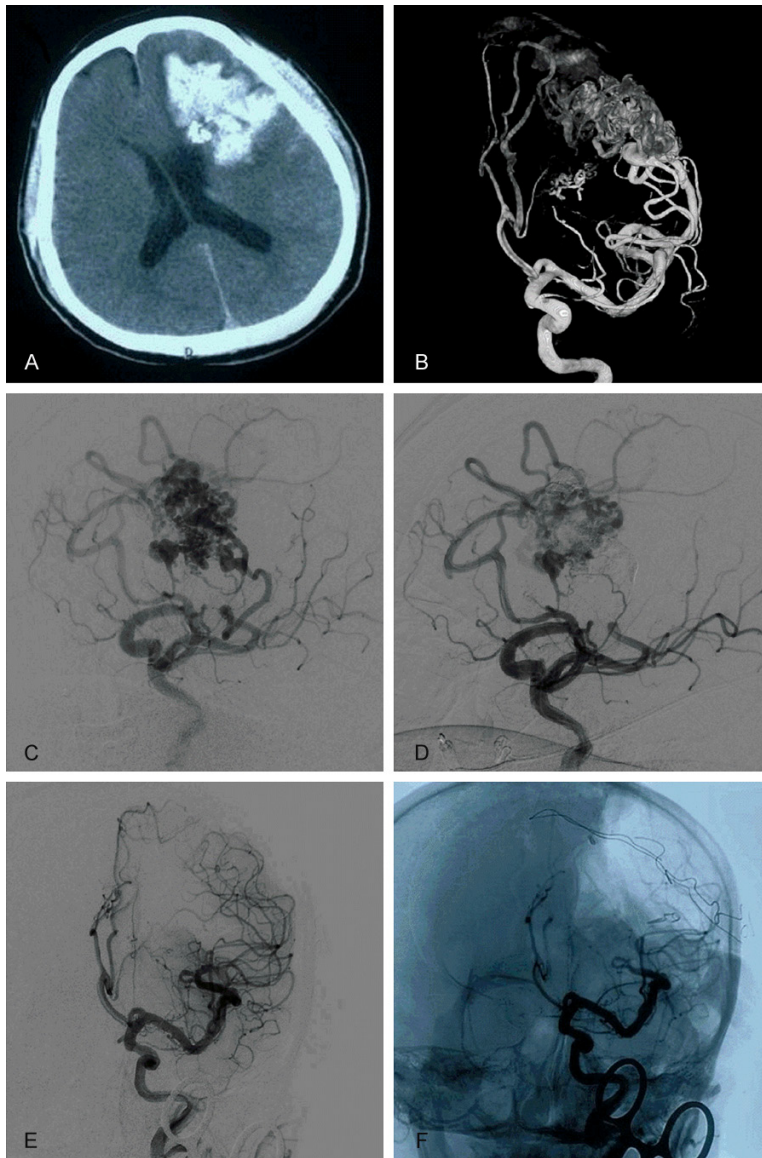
Images from the patient in case 4. A: Head CT shows the hematoma in the left fronto-parietal lobe; B: Head 3D-DSA shows the AVM in the left fronto-parietal lobe, which is fed by the ACA and MCA at the end, and participation of the left lenticulostriate artery in the blood supply; C: The blood supply artery of the AVM is located at the optimal projection angle; D: The AVM was completely embolized with the best working angle; E, F: DSA immediately after the operation shows total resection of the AVM.
